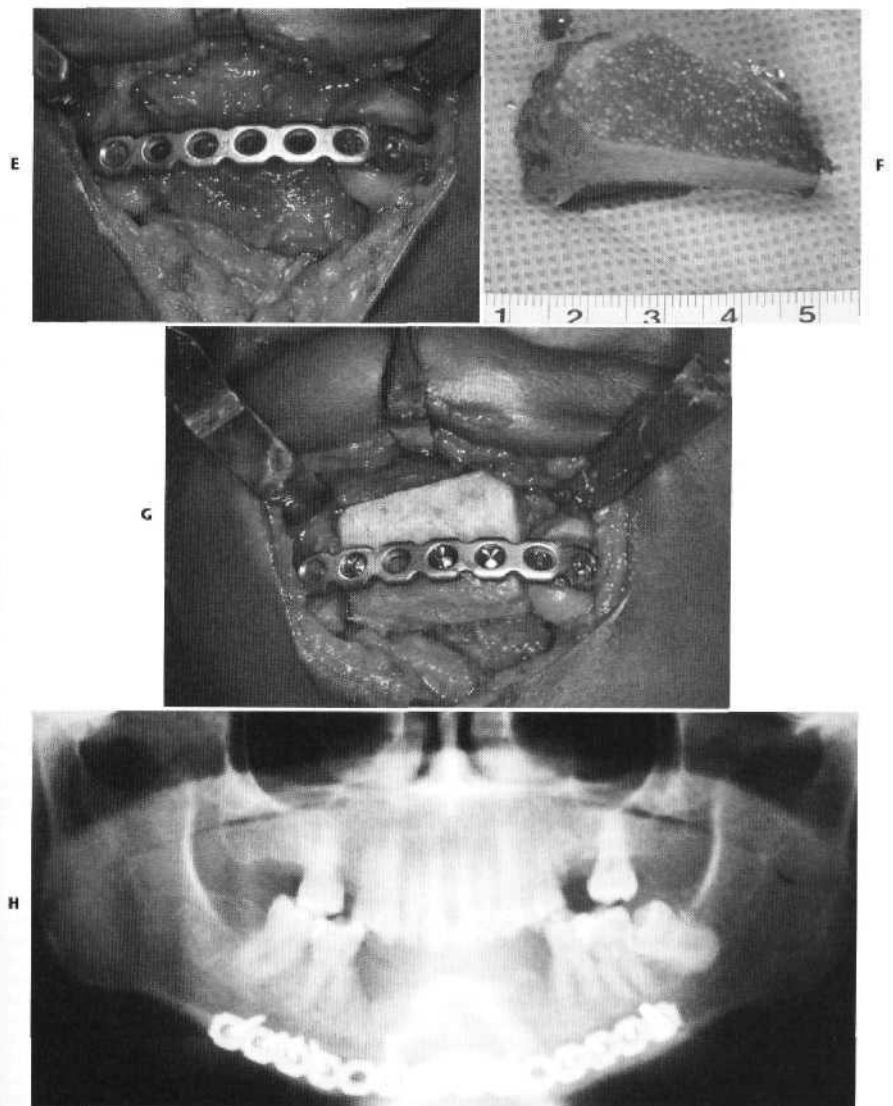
cont'd E, Surgical exposure using an extraoral approach. F, Full-thickness bone graft harvested from the ilium along with particulate marrow and cancellous bone to use as "filler" and to provide osteocompetent cells. G, Bone graft attached to the bone plate, particulate bone is then packed around the area to promote bone healing. H, Panoramic radiograph taken 6 months later showing bone fill and healing of graft to both mandibular halves.
